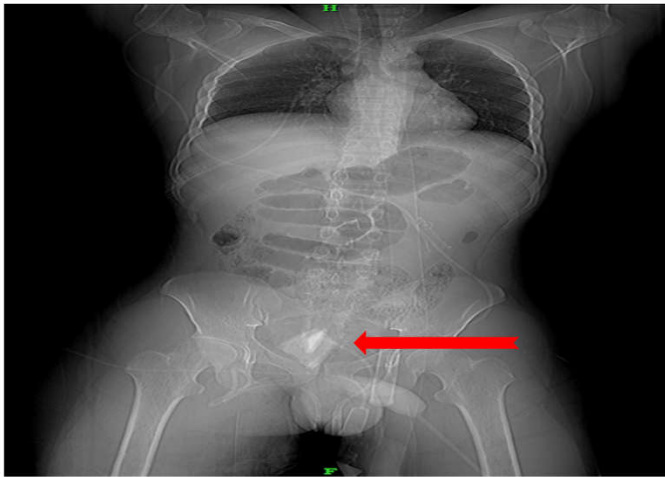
X-ray abdomen and pelvis showing foreign body in pelvis (Red arrow pointing foreign body)
